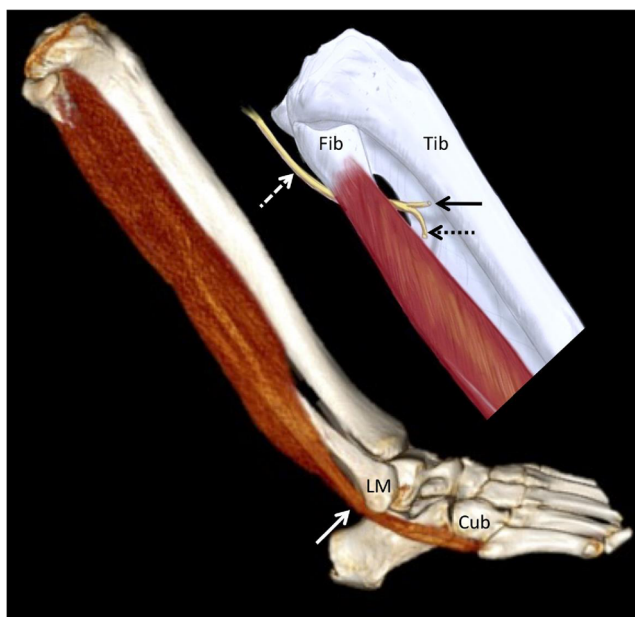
Normal anatomy of the peroneus longus. The peroneus longus muscle and tendon are shown on a 3D CT reconstruction. The distal tendon has a unique, long course with two turns at the retromalleolar region (*white arrow*) and beneath the cuboid in the cuboid tunnel (not shown) before entering the plantar foot. The inset graphic shows the common peroneal nerve (CPN- *dashed white arrow*) superficial to the fibula before passing between the peroneus longus and fibula neck in the peroneal tunnel. The CPN then divides into the deep (*black arrow*) and superficial (*dashed black arrow*) peroneal nerves along with a small recurrent articular branch (not shown). The superficial peroneal nerve innervates the peroneus longus muscle. *LM* lateral malleolus, *Cub* cuboid, *Fib* fibula head, *Tib* tibia
